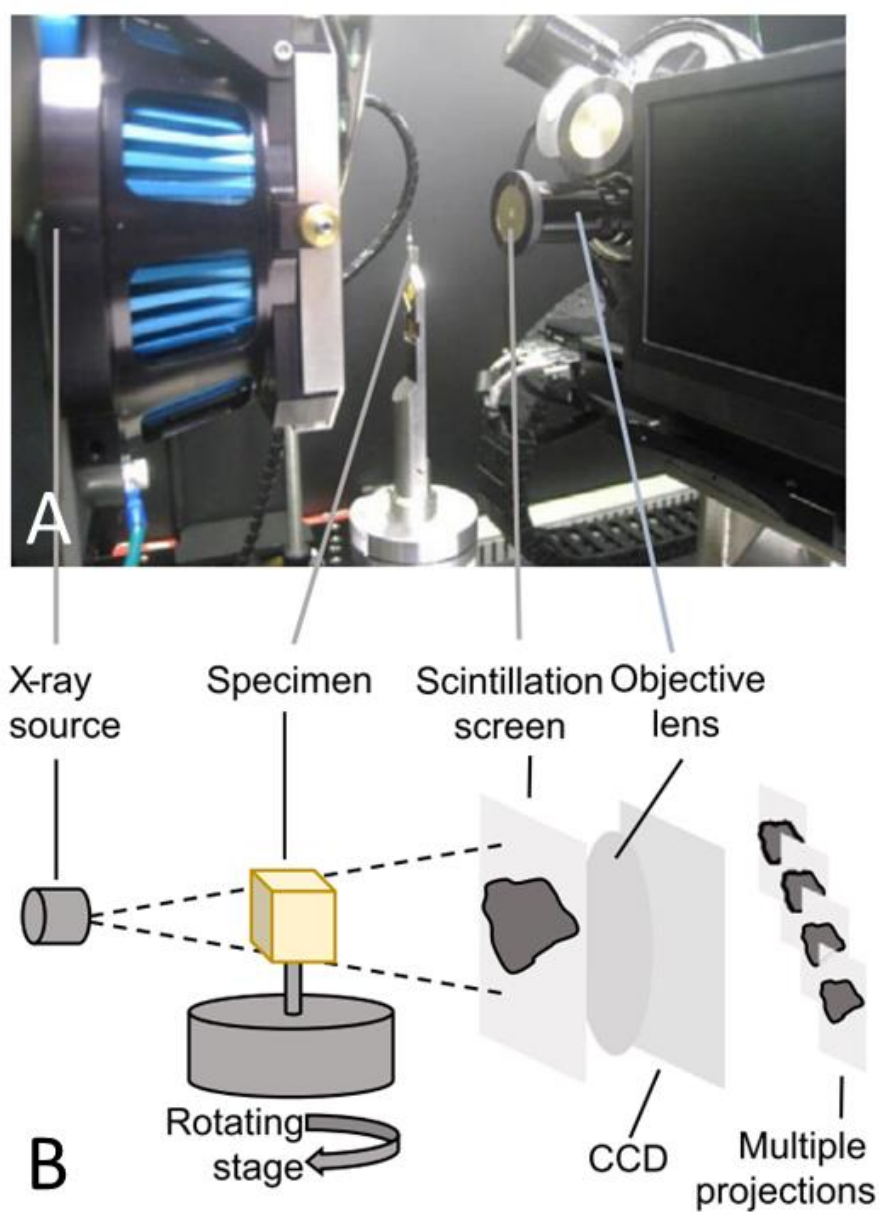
Principle of μ CT
